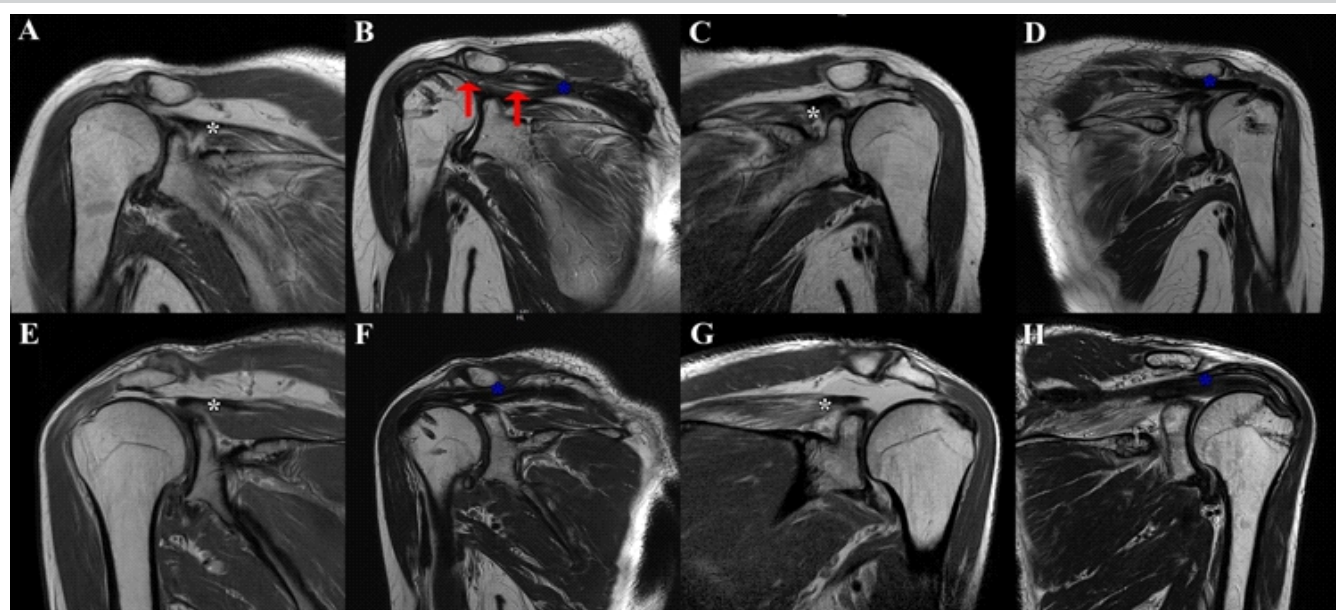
Bilateral shoulder magnetic resonance imaging. Patient 1: Pre-operative (a) and post-operative (b) right shoulder; pre-operative (c) and post-operative (d) left shoulder. Patient 2: Pre-operative (e) and post-operative (f) right shoulder; pre-operative (g) and post-operative (h) left shoulder. White asterisk, supraspinatus; blue asterisk, interpositional graft; red arrow, partial retear of the graft.
